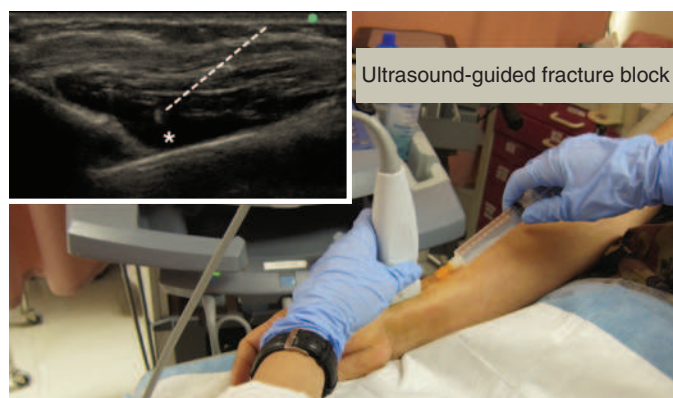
Ultrasound-guided fracture block for a distal radius fracture. Ultrasound can be used to identify most long-bone fractures quickly and definitively as a discontinuity in the brightly echoic cortical surface. At the fracture site, the needle (dashed line) is guided with ultrasound visualization to the disrupted periosteal surface, where local anesthetic is injected. Any long-bone fracture can be managed with a fracture block. Care should be taken to maintain sterility and not to exceed recommended maximum local anesthetic dosing.
